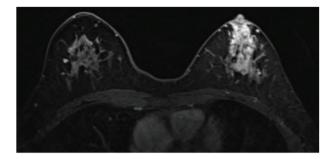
Contrast-enhanced magnetic resonance imaging showing a 51x21-mm non-mass-enhancing lesion extending to the nipple in the left breast.
